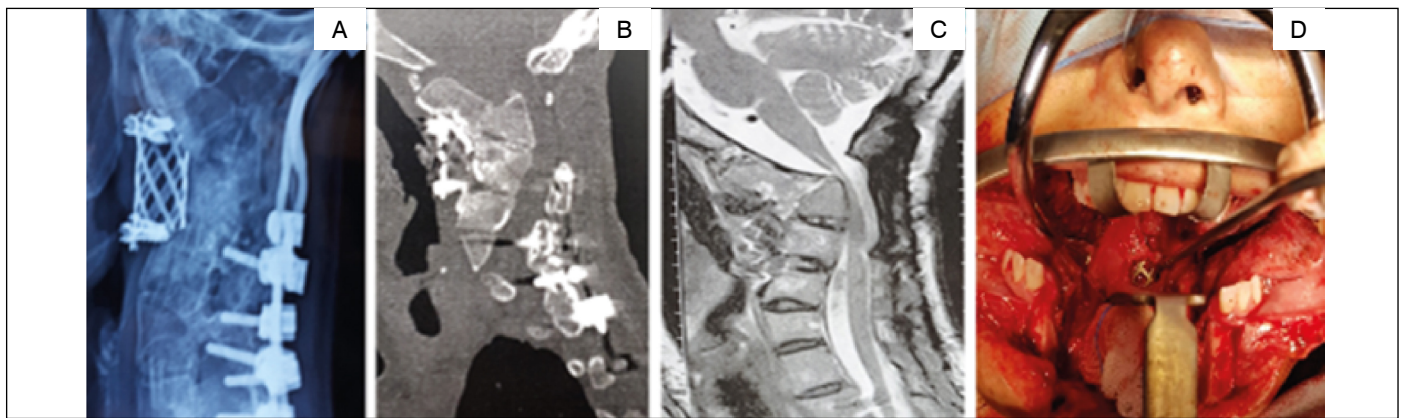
A – X-ray showing displaced cage. B – Bone growth behind the cage. C – MRI showing medullary compression. D – Dehiscence of the pharyngeal wall.
